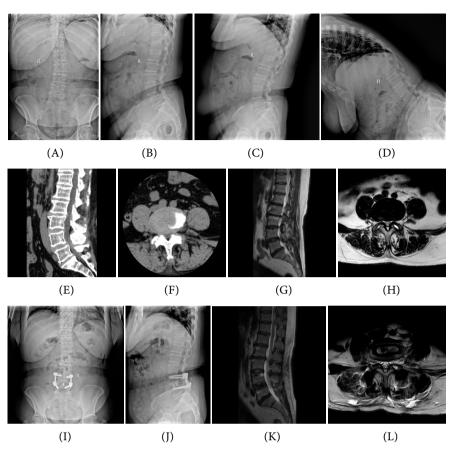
Imaging pictures of patients with lumbar spondylolysis type spondylolisthesis before and after surgery ((A-D) preoperative X-ray showed L4 vertebral instability with degree I spondylolisthesis; (E-F) preoperative CT showed bilateral spondylolysis of L4 vertebral body; intraoperative localization of responsible segments; (G-H) preoperative MRI showed no compression in the vertebral canal intraoperative height of L4 - L5 intervertebral space after the placement of OLIF fusion cage; the recovery is good, and the slipping reset is good; (I-J) Postoperative X-ray showed that L4 - L5 intervertebral space height recovery and spondylolisthesis reduction were good and stable; (K-L) Postoperative MRI showed good reduction of spondylolisthesis and no compression in the spinal canal).
